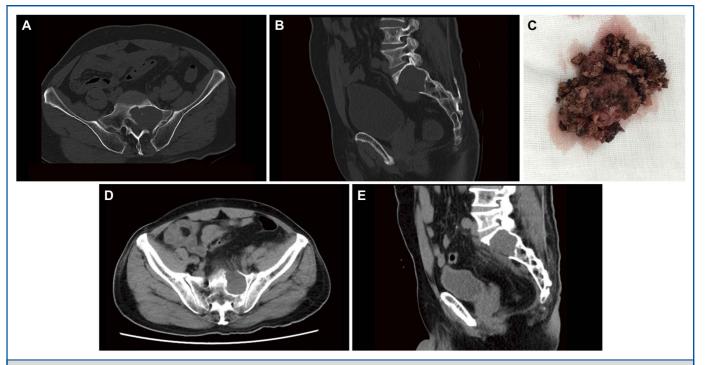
A 71-year-old man diagnosed with schwannoma (case 11 from Table). A and B, The tumor was classified as type III according to preoperative computed tomography. C, Gross view of the tumor after an intralesional partial resection. D and E, No progression was observed during a 15.1-month follow-up.
